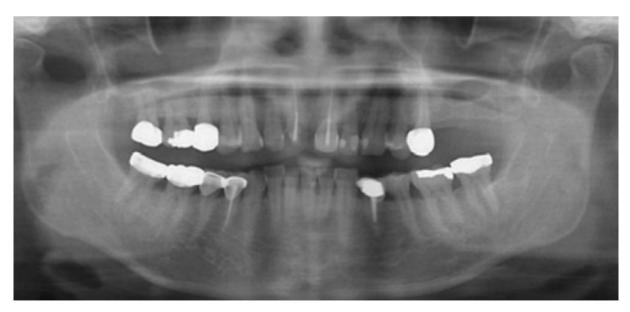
Panoramic radiograph in the first dental examination. The residual bone at the first and second molar parts on the left side of the upper jaw is estimated to be about 4-5mm high.
